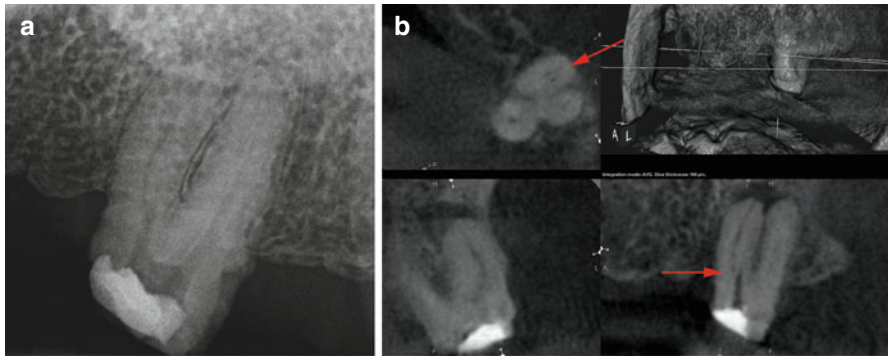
(a) Periradicular radiograph of maxillary second molar tooth. (b) CBCT the same maxillary second molar tooth showing the position of the MB canal in relationship to the previous attempt to access this canal (*red arrow*)
